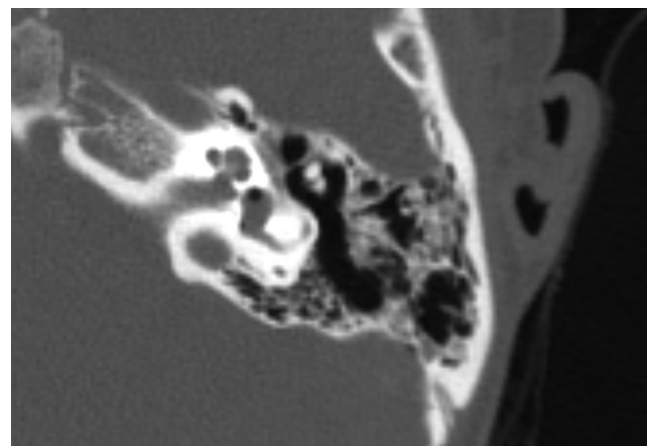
Case 2: Pneumolabyrinth in the vestibule. Image is axial CT of the left ear.
